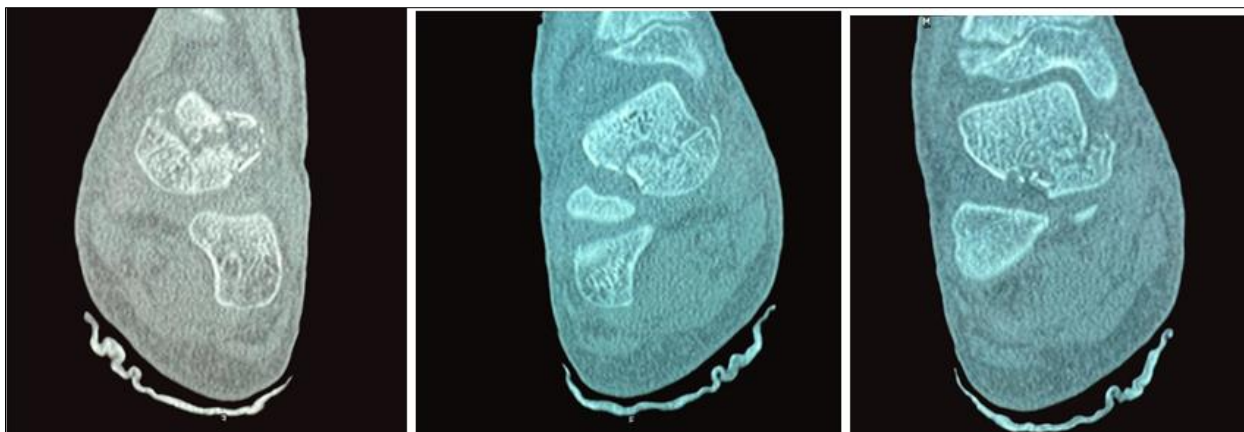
Different CT scans of the ankle showing comminuted fracture of the talus
